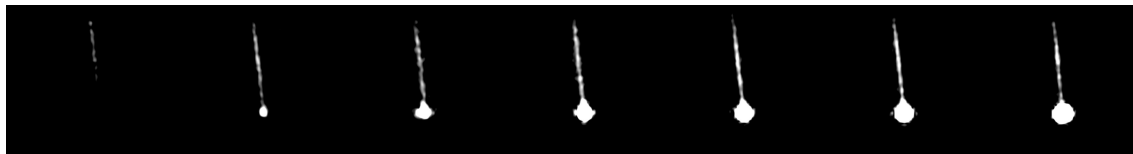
(above) Dynamic ³He MRI time series of the inflation of the catheter tip. The signal from the catheter feed channel is also well visualized.
